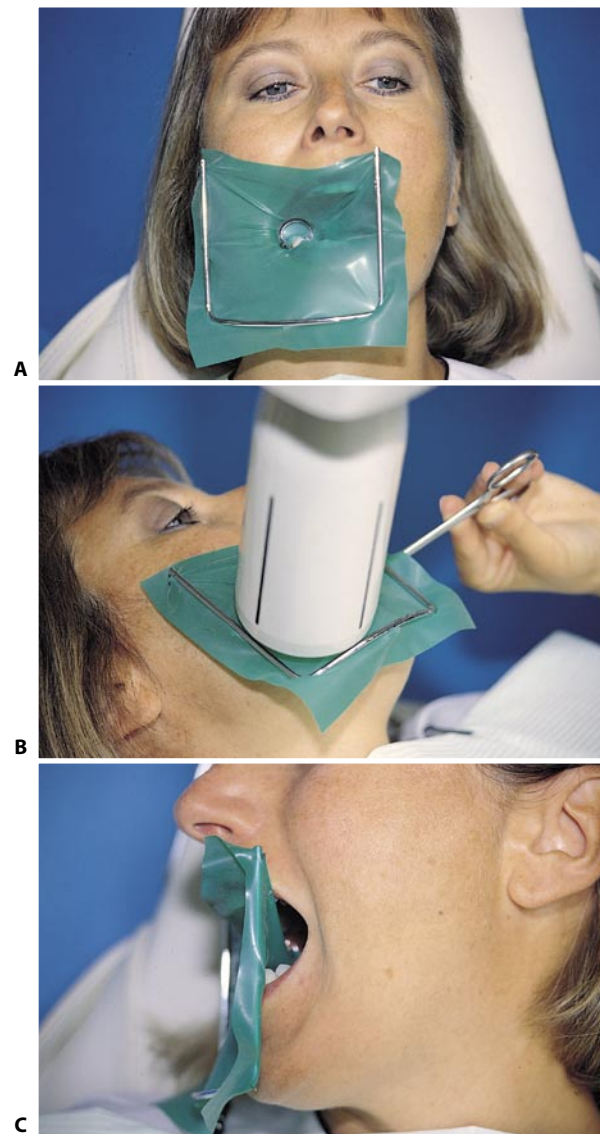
A. The opening has been made more or less within the center of the dam, which is asymmetrical with respect to the patient's face. B. In this way, the metallic frame does not interfere with the X-ray machine. C. The patient can also breathe through the mouth.
